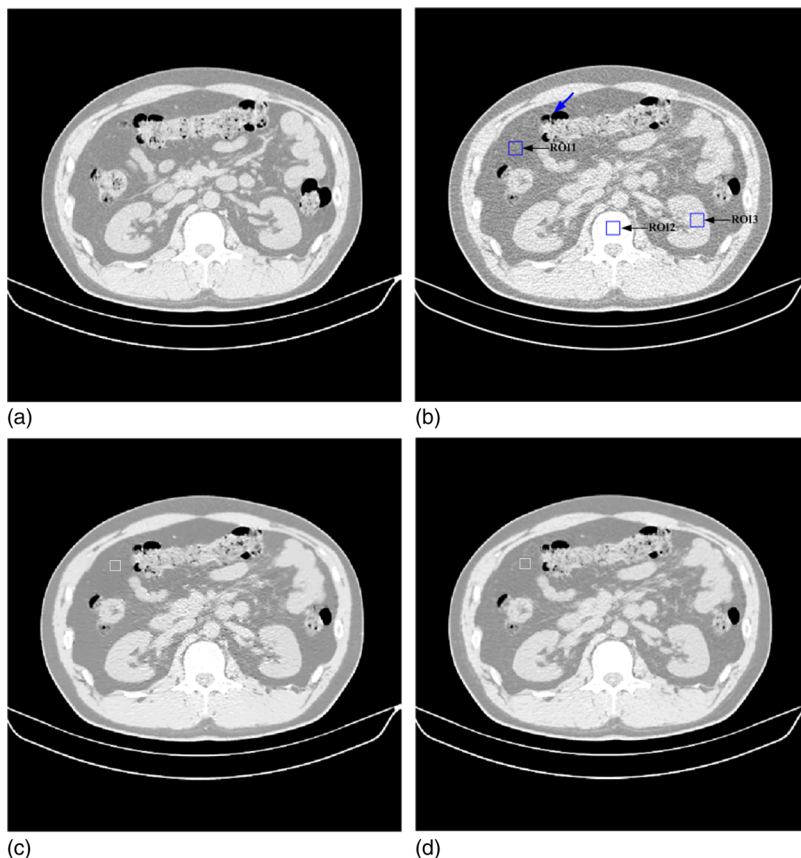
Clinical abdominal CT image restorations: (a) the normal-dose scan acquired with 130 kVp, 200 mAs protocol and a standard B40s reconstruction kernel; (b) the low-dose scan acquired with 130 kVp, 30 mAs protocol and a standard B40s reconstruction kernel; (c) the restored image from the low-dose scan using the NLM algorithm ( $N_i = 41 \times 41$ ,  $V_i = 5 \times 5$ ,  $\tau = 2.44 \times 10^{-4}$ ); and (d) the restored image from the low-dose scan using the ndiNLM algorithm, where the registered reference image from the normal-dose scan (a) was used as a reference image ( $\tilde{N}_i = 41 \times 41$ ,  $\tilde{V}_i = 5 \times 5$ ,  $\alpha = 1.95 \times 10^{-4}$ ). Display window option: width is 545 HU, level is  $-169$  HU.
